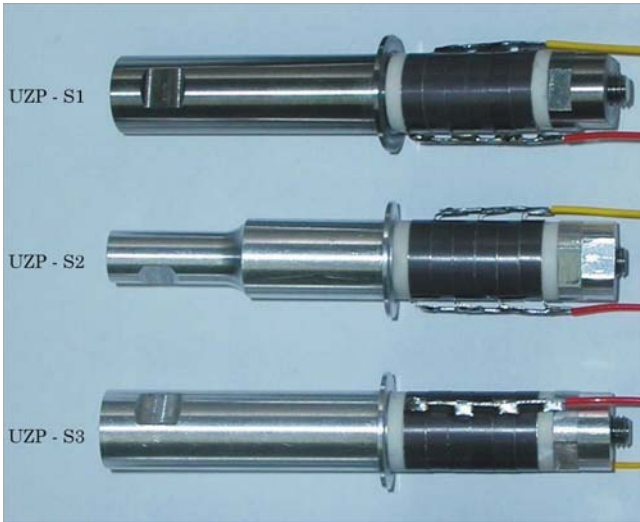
Ultrasonic transducers used for this study
